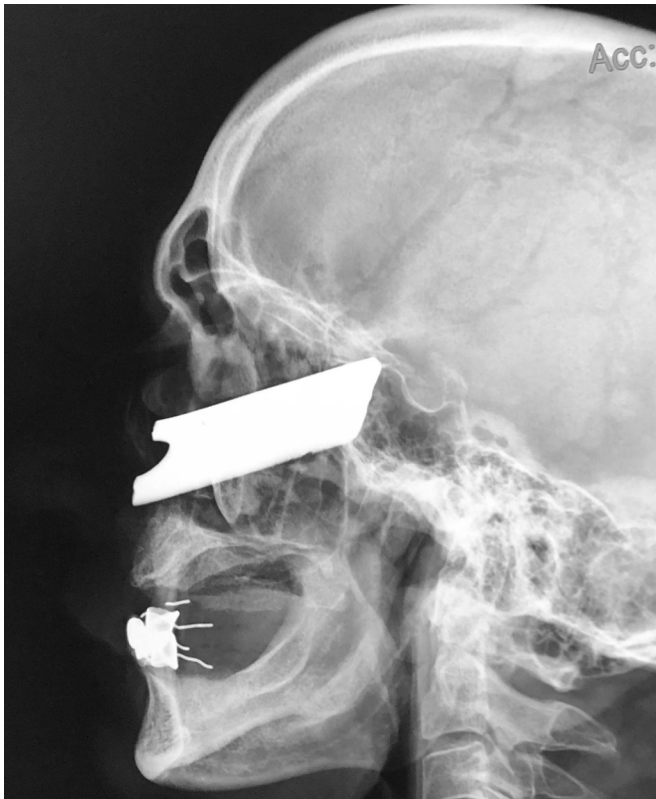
Lateral X-ray scan.
